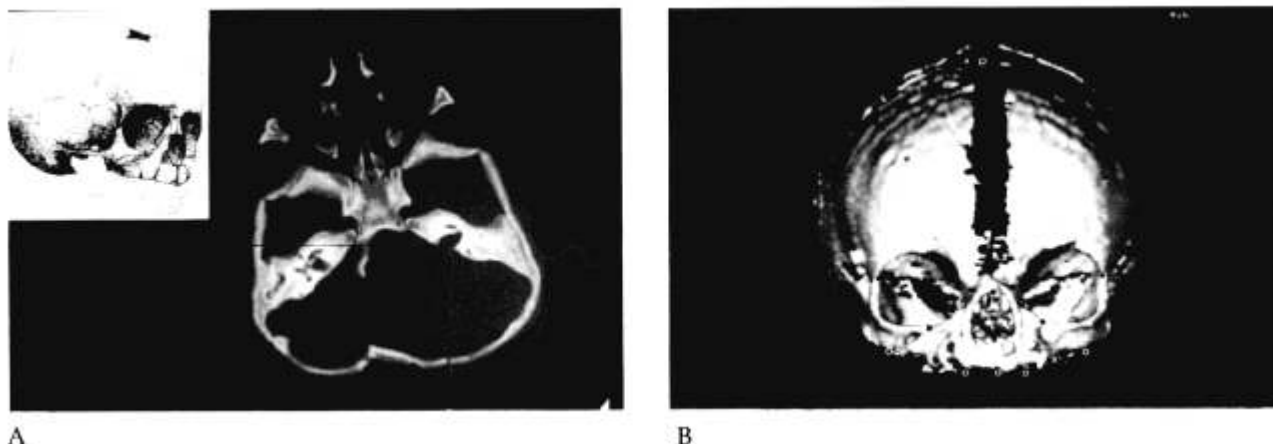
Two ways to locate landmarks on computed tomographic (CT) scans. (A) Locating a landmark in X and Y spaces on a CT slice image is shown. X and Y coordinates are located according to pixel column and row. Z coordinates (in this case the superior-inferior dimension) are assigned according to the table position of the slice in which the landmark is located. (B) Locating landmarks on three-dimensional CT reconstruction is shown in which the landmark is located in a local coordinate space according to X, Y, and Z coordinates. (Adapted from Richtsmeier [58].)
